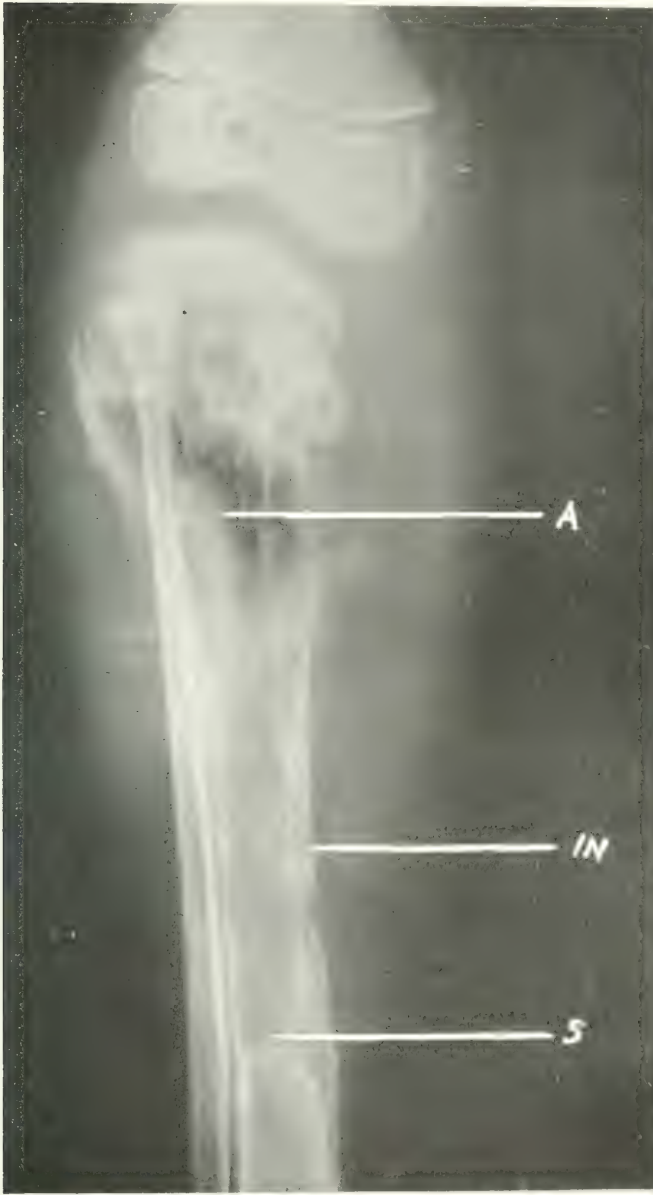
Clinical case No. 9. X-ray July 30, 1910. Operation June 22, 1910. Removal two inches of anterior surface upper third of tibia. A, area of bone removed at primary operation; In, involucrum; S, separation zone.
